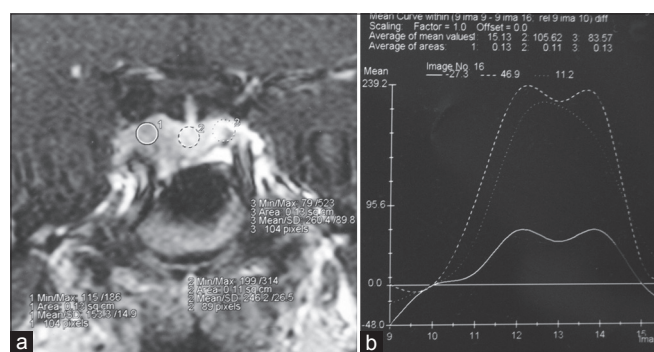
MRI showing (a) multiple microadenomas and (b) with dynamic mean curve analysis
